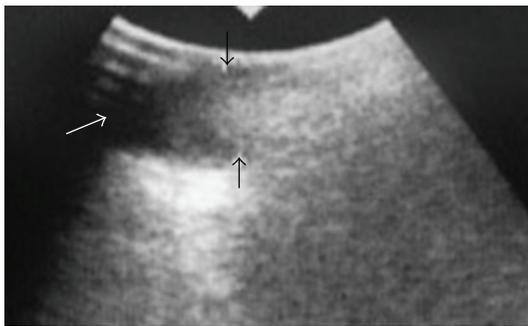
View of the imperfect examination (white arrow) using intra-oral ultrasonography because the tumor is located near the base of the tongue in a 67-year-old man with carcinoma (arrows) on the left side of the tongue.
